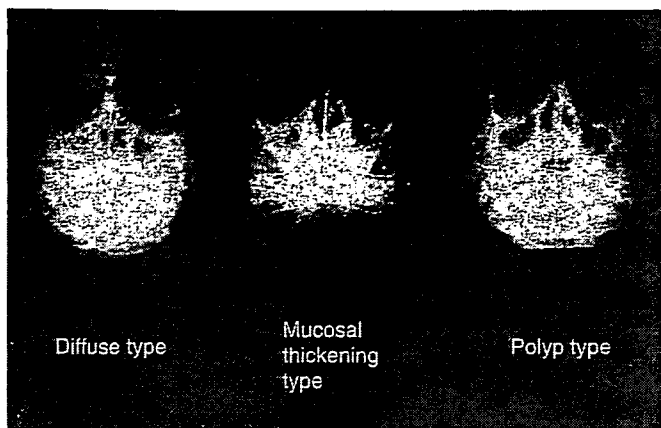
Waters radiographic view of a patient with allergic and/or infectious rhinosinusitis. Types of shadow demonstrated in the picture are diffuse, mucosal thickening, and polyp. Relatively higher incidence of mucosal thickening and polyp type are seen in patients with allergic rhinitis. The diffuse type is found frequently in cases with infectious rhinosinusitis.
